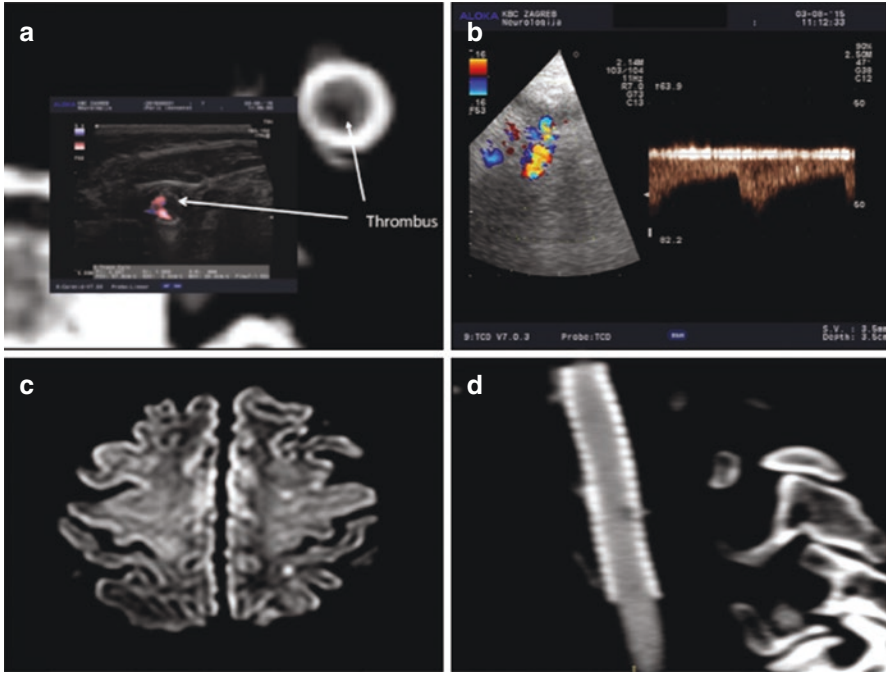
A patient with aspirin resistance. (a) Carotid duplex and CT angiography show formation of in-stent thrombus in left ICA. (b) TCCS examination of ICA through submandibular window detects HITS. (c) DWI imaging reveals zones of signal restriction ipsilateral to in-stent thrombosis. (d) Resolution of thrombus in CTA 3 days after initiation of dual antiplatelet therapy
